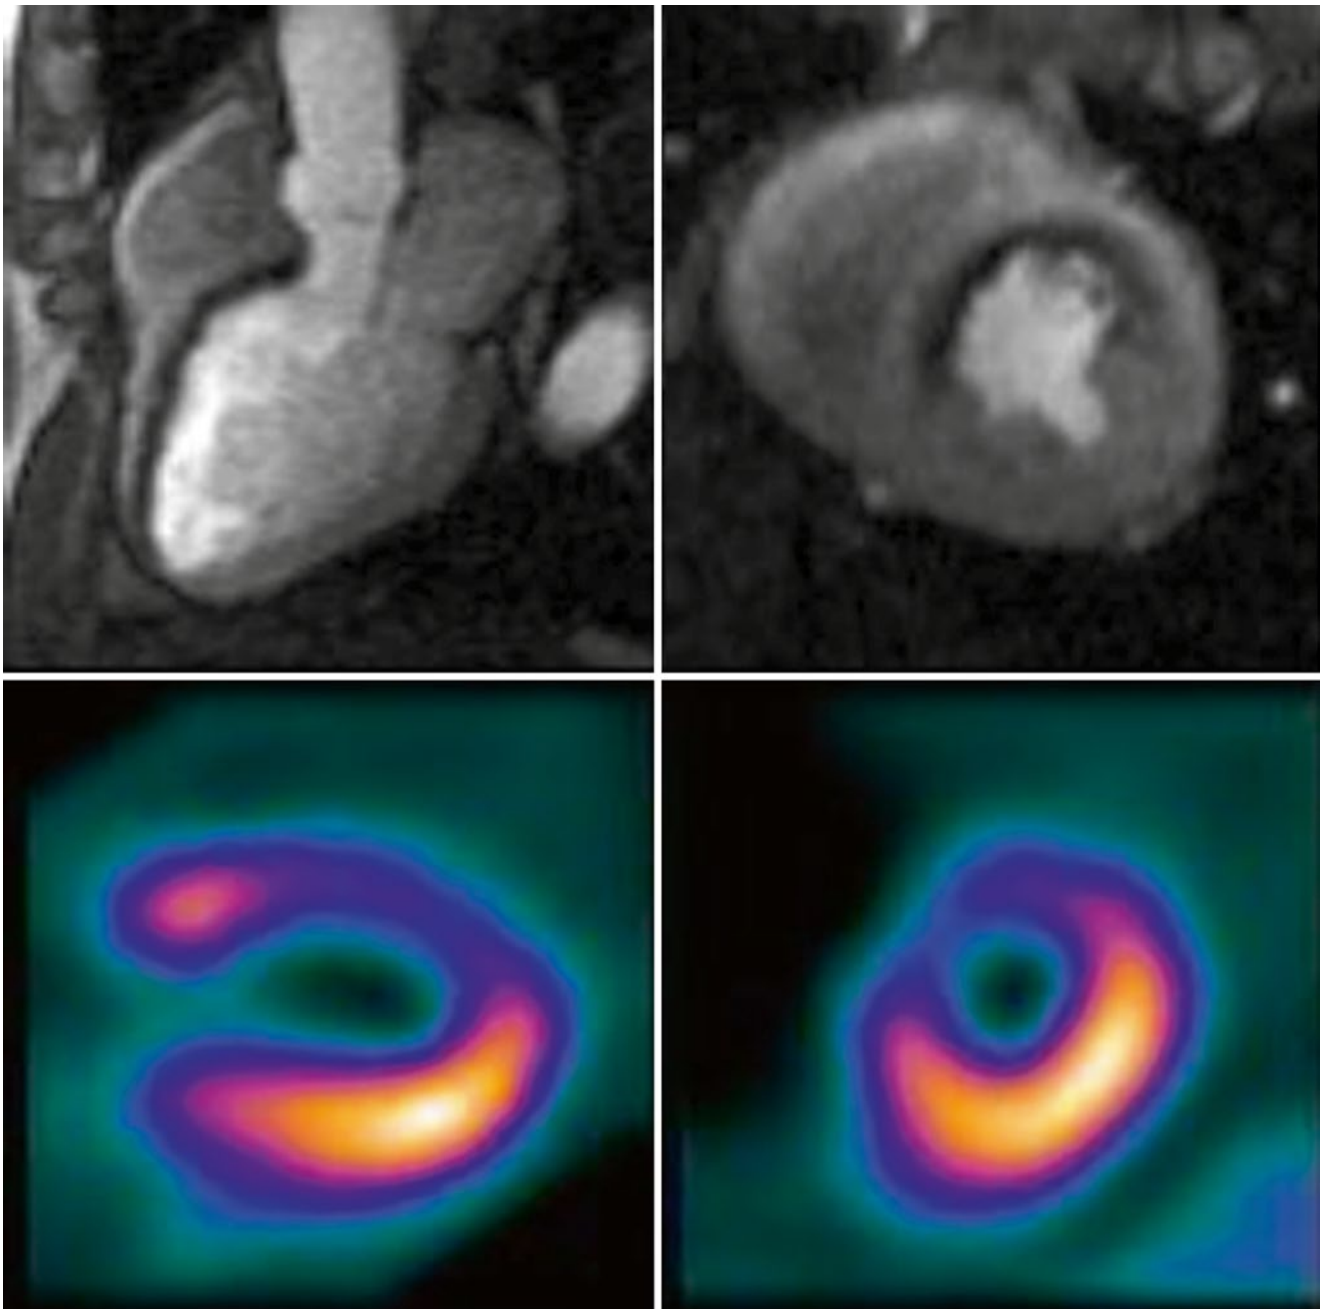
Severe ischemia in the distribution of the left anterior descending coronary artery seen by MR perfusion (*top row*) and SPECT imaging (*bottom row*). A single frame from the first-pass MR perfusion series demonstrates severe ischemia of the anteroseptum from base to
